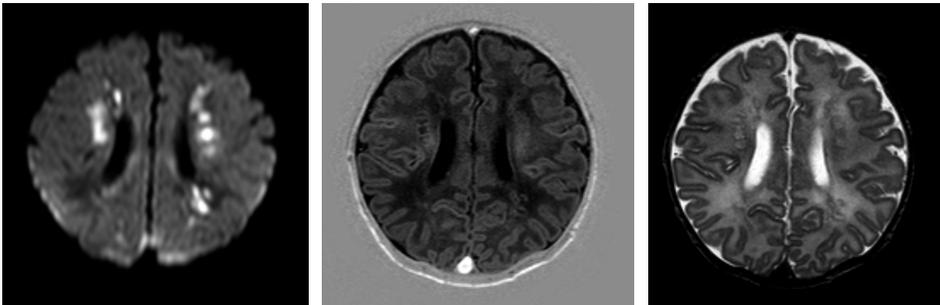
An example of severe WMI in a patient with an aortic arch obstruction. Left: diffusion weighted imaging (DWI) shows areas of restricted diffusion in white, which suggest recent injury; middle: T1; right: T2 imaging.
